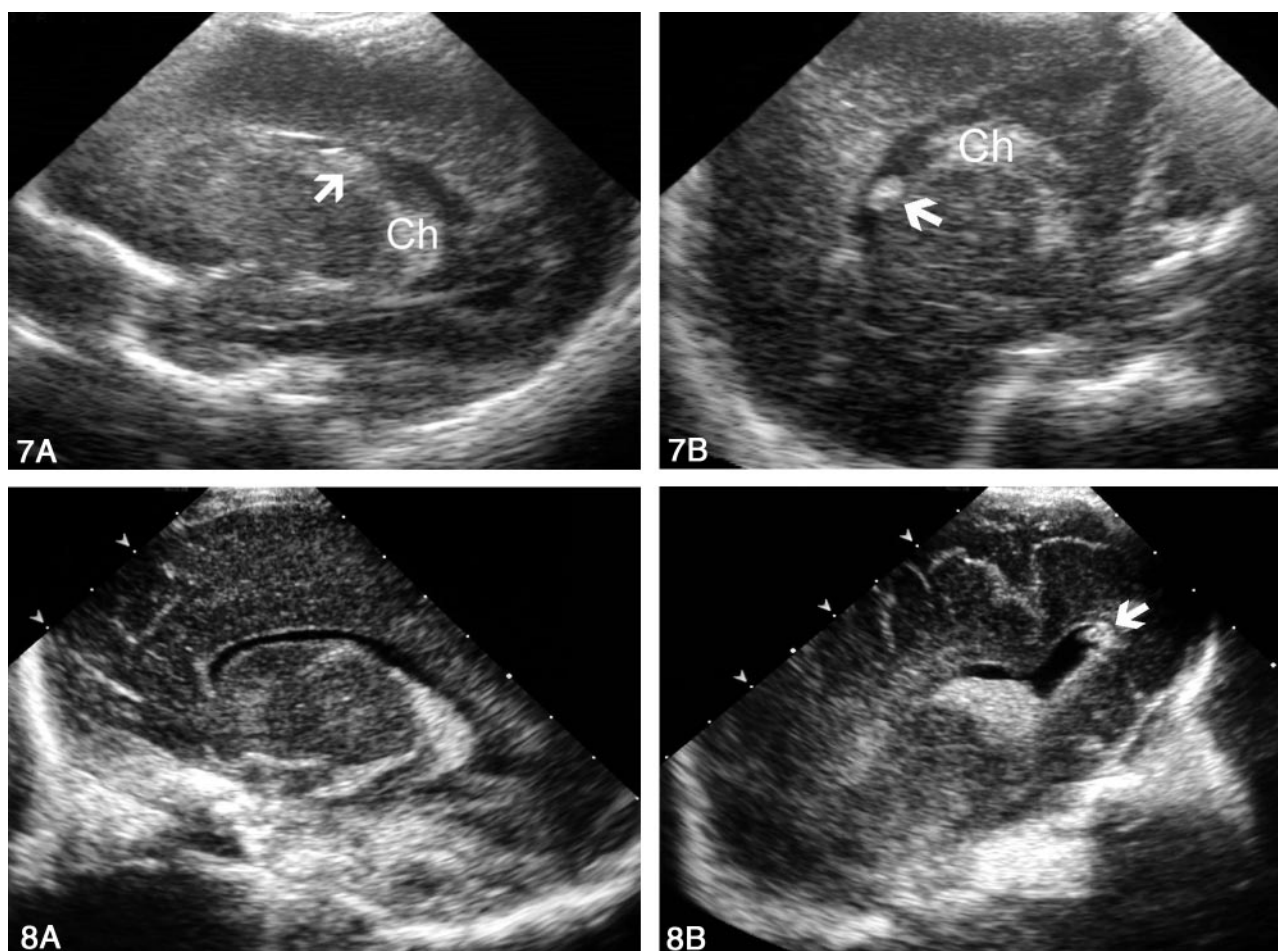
Sonograms obtained in a premature neonate with grade I hemorrhage that was better delineated through the PF than through the AF.
